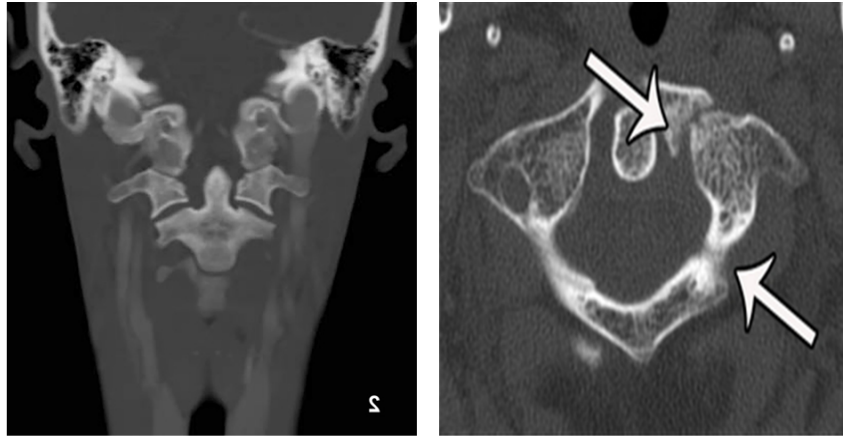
Coronal CT reconstruction showing bilateral transverse foramina and side-wise asymmetry.
